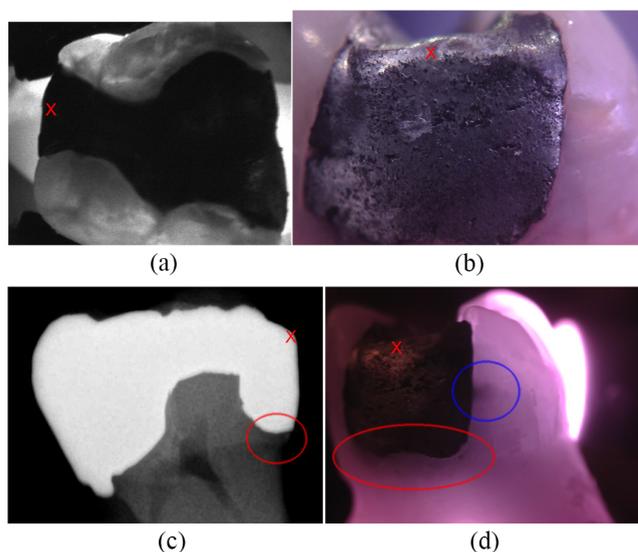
Multiple images of an amalgam filling under different imaging modes. The presence of the metal amalgam inhibits assessment. The red “X” denotes the same amalgam edge in all images. (a) The DEXIS CariVu’s occlusal imaging shows some demineralization. (b) White light examination reveals no immediate problems. (c) Amalgam appears opaque in the two-dimensional radiograph and blocks evaluation of superimposed tooth material. Secondary caries has started in the lower amalgam margin, as circled in red. (d) Scanning of the amalgam margin with the NIR system shows secondary caries along the bottom of the amalgam circled in red, as seen in the radiograph in (c). Midway down the side of the filling, circled in blue, was another secondary caries spot undetected by the other imaging methods. No indication of this caries is present in the white light image in (b). (a) was taken *in vivo*, and (b)-(d) were taken after extraction.
